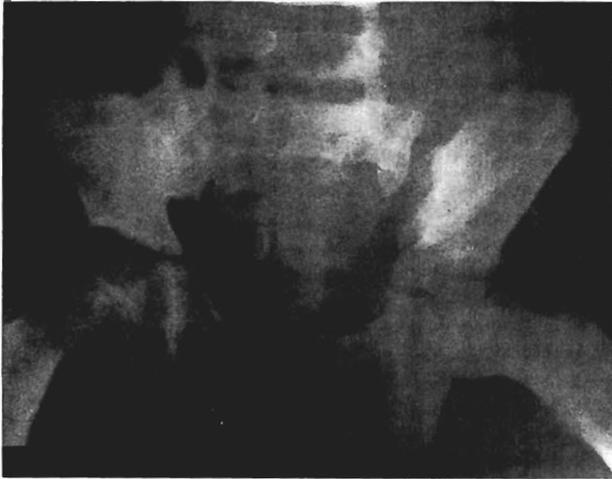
Crushed by a car, this 8-year-old girl was admitted with hypotension, a large laceration, a left obturator, sciatic nerve palsy, and vaginal bleeding. Radiographs disclosed fracture of the left pubic ramus and disruption of the sacroiliac joint. She received 4 litres of blood, and extraperitoneal hemorrhage was controlled with packs.
